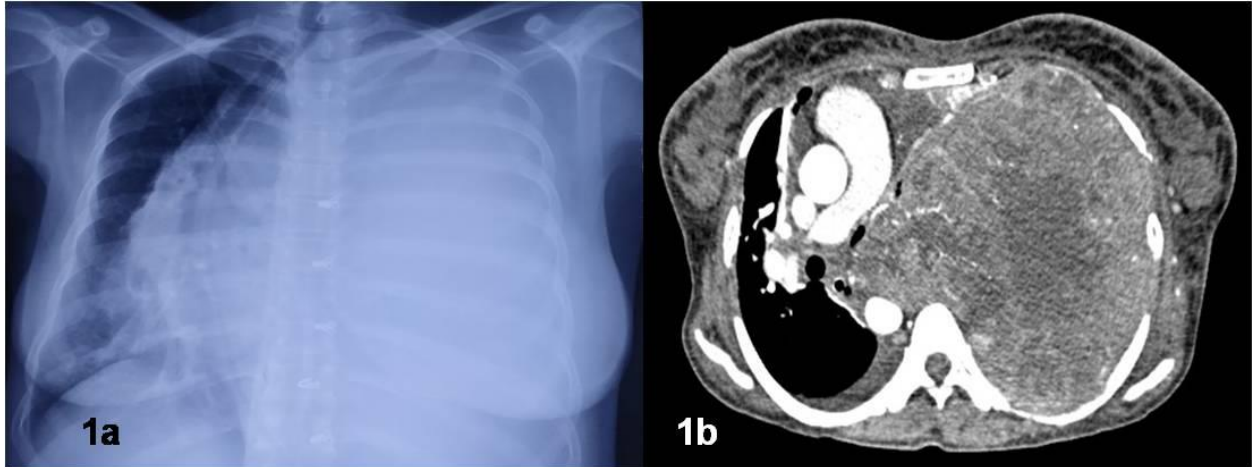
A: Chest Radiography showing whiteout left hemithorax and gross contralateral shifting of mediastinal structures. B: CT Thorax (mediastinal window) at level T-5 showing a huge mass lesion virtually replacing left lung and gross contralateral shifting of mediastinum. The mass lesion has various necrotic areas interspersed in between.
